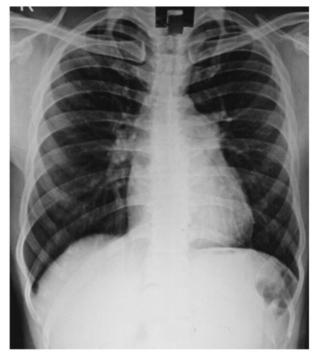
Chest xray showing prominent main pulmonary artery and bilateral dilated pulmonary arteries
